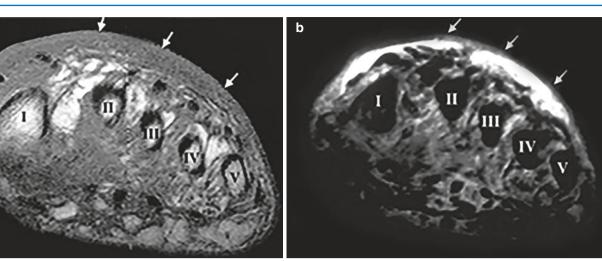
Dorsal soft tissue swelling on MRI. (a) T1-weighted image and (b) fluid-sensitive STIR image are coronal or short axis images acquired at the level of the mid metatarsal shafts. This diabetic patient has diffuse dorsal soft tissue swelling (small arrows). The subcutaneous edema is dark or low signal on the T1-weighted image and bright or
